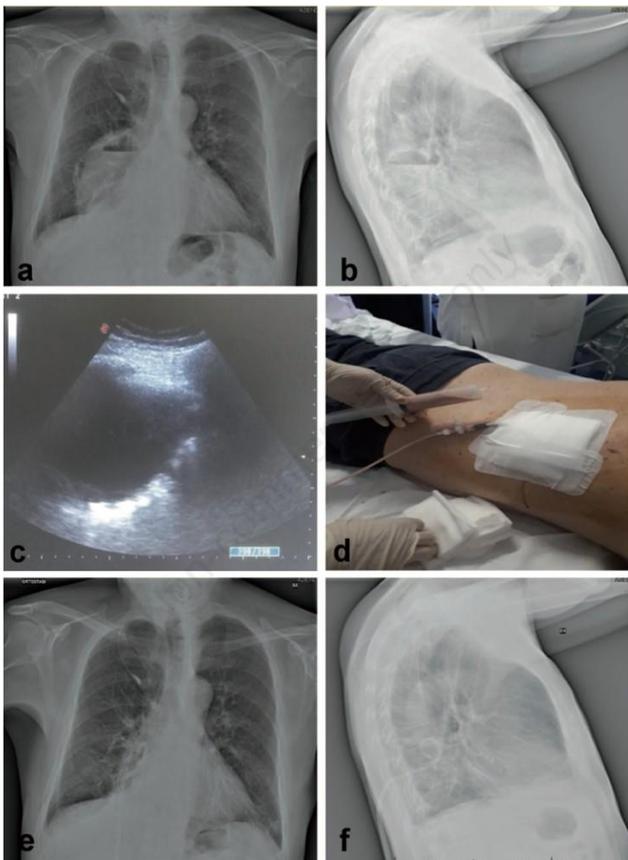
a) & b) PA and Lateral chest X-ray before percutaneous drainage; c) Thoracic ultrasound before percutaneous drainage; d) Percutaneous drainage; e) & f) PA and lateral chest X-ray 5 days after percutaneous drainage.<sup>20</sup>
